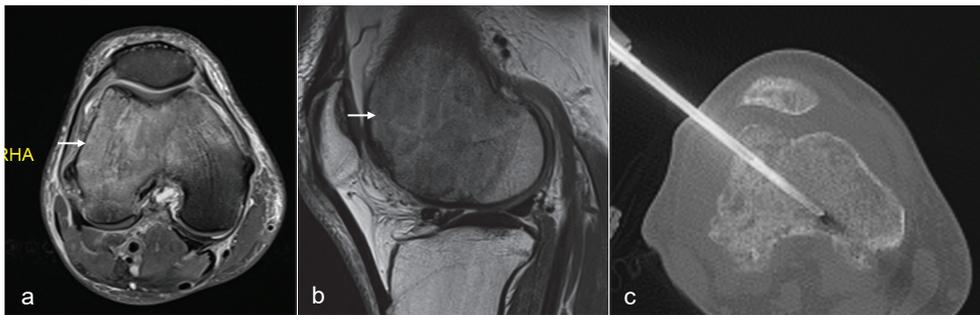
Axial T2fat suppressed (a), sagittal Proton density (b) showing tumour in the distal femur. Axial CT (c) showing biopsy needle in the distal femoral lesion.
